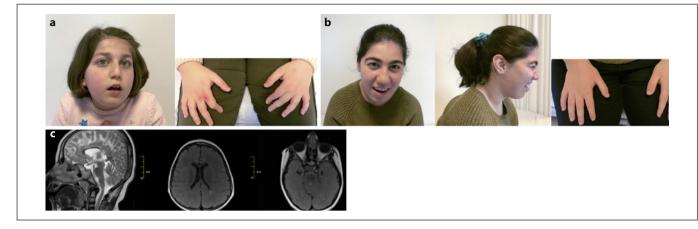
Dysmorphic features of the 2 affected siblings. a, b Brachycephaly, a round face, full cheeks, prominent nasal bridge, short philtrum, a thin upper lip, small hands. c Brain magnetic resonance imaging (performed at 5 years of age) showed corpus callosum dsygenesis (T1-weighted sagittal section, asterisk) and areas of delay in myelination at the level of bilateral trigones, prominence in the temporal horns of bilateral lateral ventricles.
